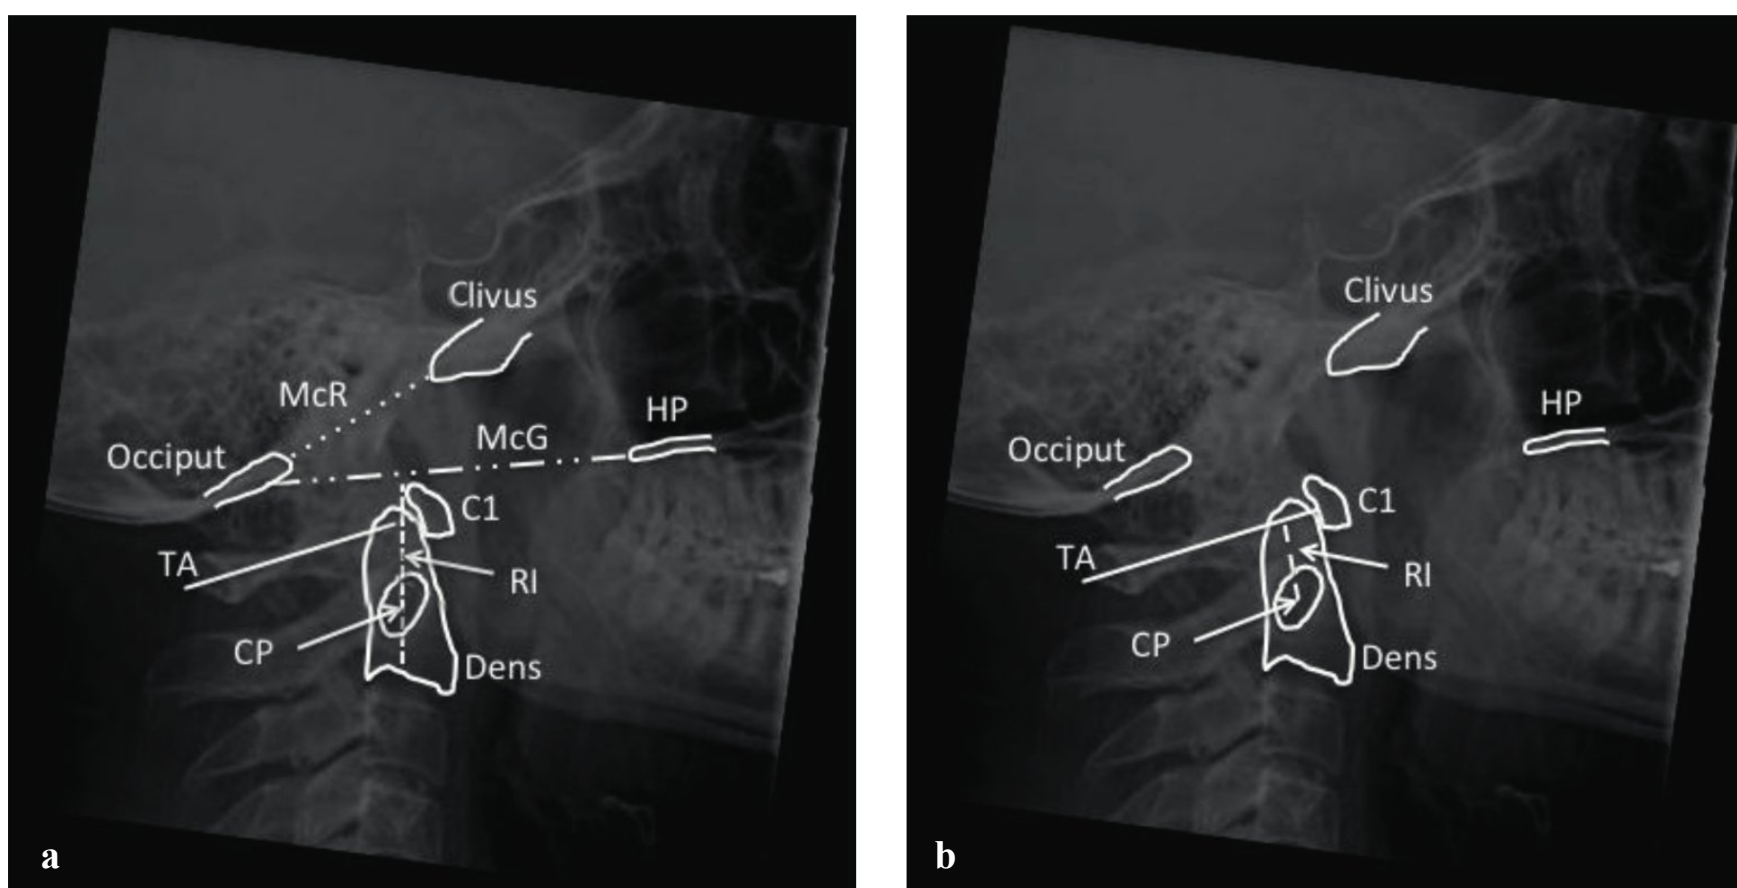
Lateral plain film radiograph demonstrating the anatomical landmarks used to draw the (a) McGregor line (McG), Redlund–Johnell line (RJ), McRae line (McR), and (b) the Ranawat index. HP, hard palate; TA, transverse axis of atlas; CP, center of pedicle of axis.
